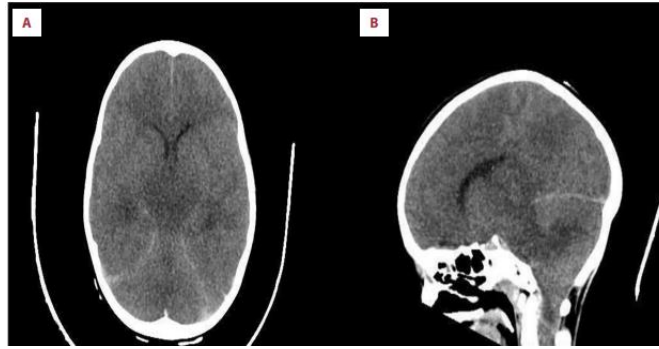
Brain CT scan soft tissue window showing significant edema with tonsillar herniation: (A): Axial view (B): Sagittal view.
